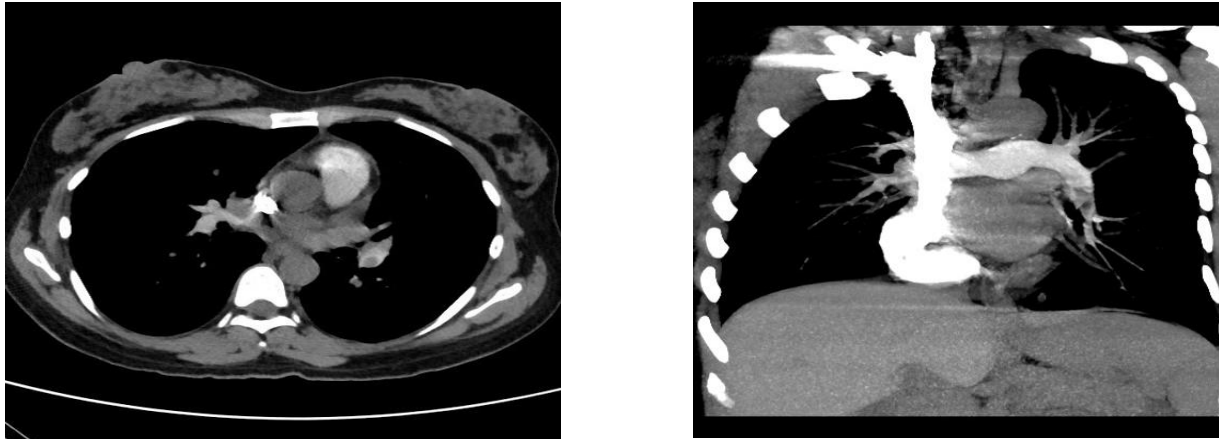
Axial section of CT pulmonary angiogram showing thrombus in left inferior lobar pulmonary artery. MIP image, coronal section showing filling defect in left inferior pulmonary artery.
